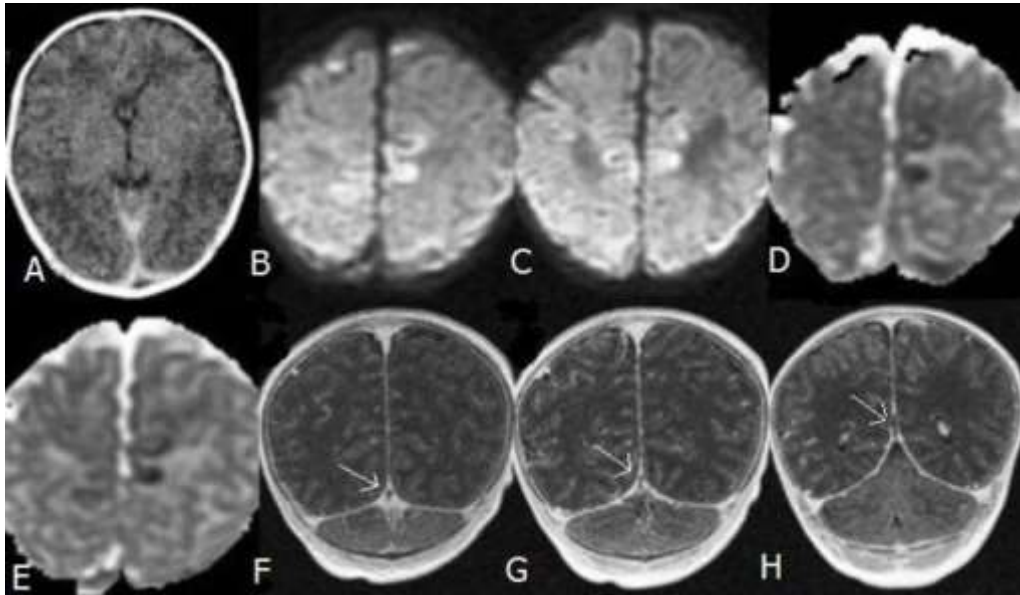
A term infant with cerebral sinovenous thrombosis who presented at the age of 20 days with decreased feeding, lethargy and generalized seizures. A) Initial CT head demonstrating evidence of poor grey and white matter differentiation, sulcal effacement and small ventricles consistent with diffuse cerebral edema and presence of hyperintensity along the falx consistent with blood in the subarachnoid space. B and C) A subsequent MRI brain showing evidence of bilateral diffusion restriction on the diffusion weighted images with corresponding apparent diffusion coefficient map consistent with bilateral paramedian frontal lobe ischemic infarction. D, E and F) The gadolinium enhanced MR venogram demonstrating presence of filling defect in the straight and the superior sagittal dural venous sinuses confirming thrombosis in these venous sinuses (arrows).
